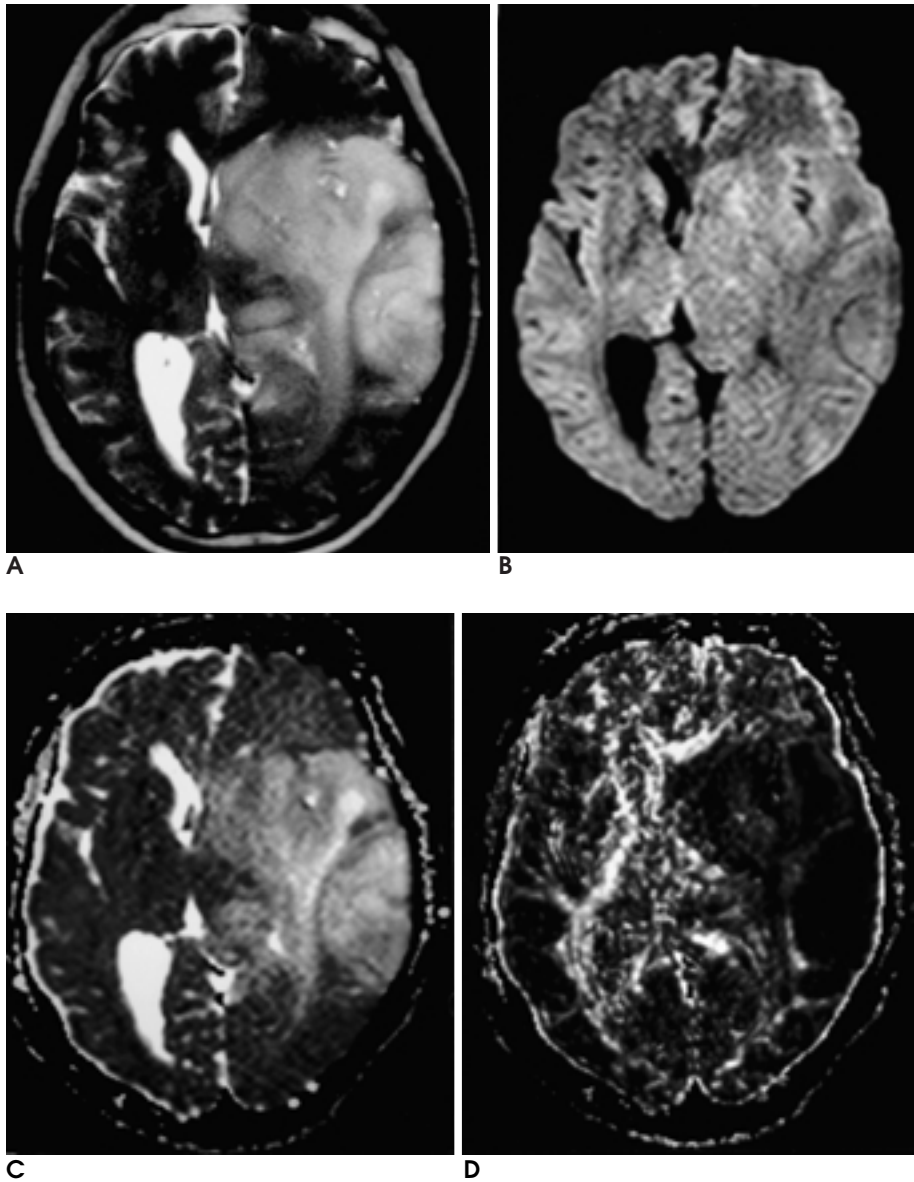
62-year-old male with gliomatosis cerebri. Diffusely infiltrating mass is seen in left temporal and frontal lobes on T2WI (A). The mass shows similar signal intensity as normal parenchyma on DWI (B). High degree isotropic ADC (C) and low fractional anisotropy (D) are demonstrated on diffusion tensor maps.
